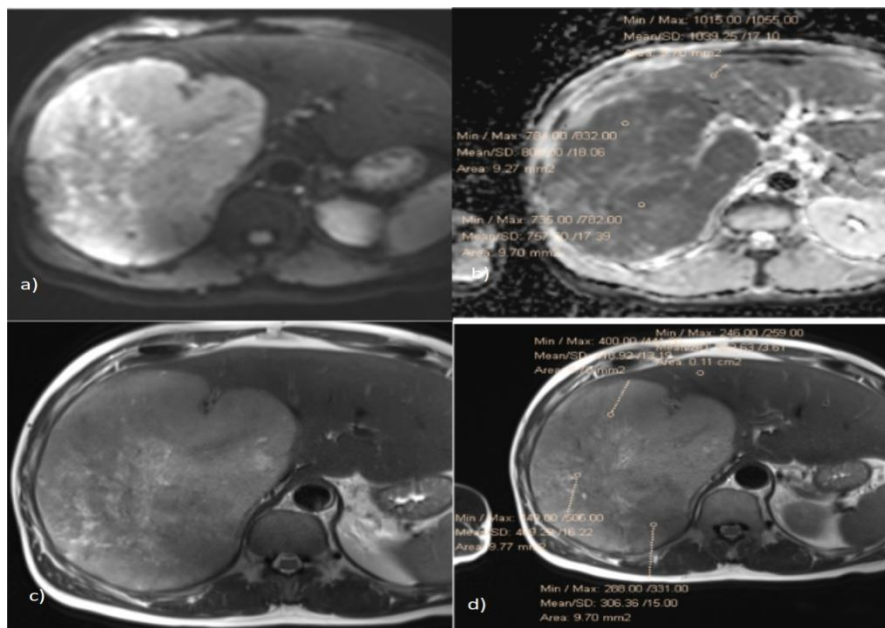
A 65-year-old man with HCC, a) &b) Axial DWI and corresponding ADC map showing areas of diffusion restriction with low b values of $0.7 \times 10^{-3} \text{mm}^2/\text{s}$; c) & d) Axial T2W image showing heterogeneously hyperintense signal and T2 signal of $0.5 \times 10^{-3} \text{mm}^2/\text{s}$.
